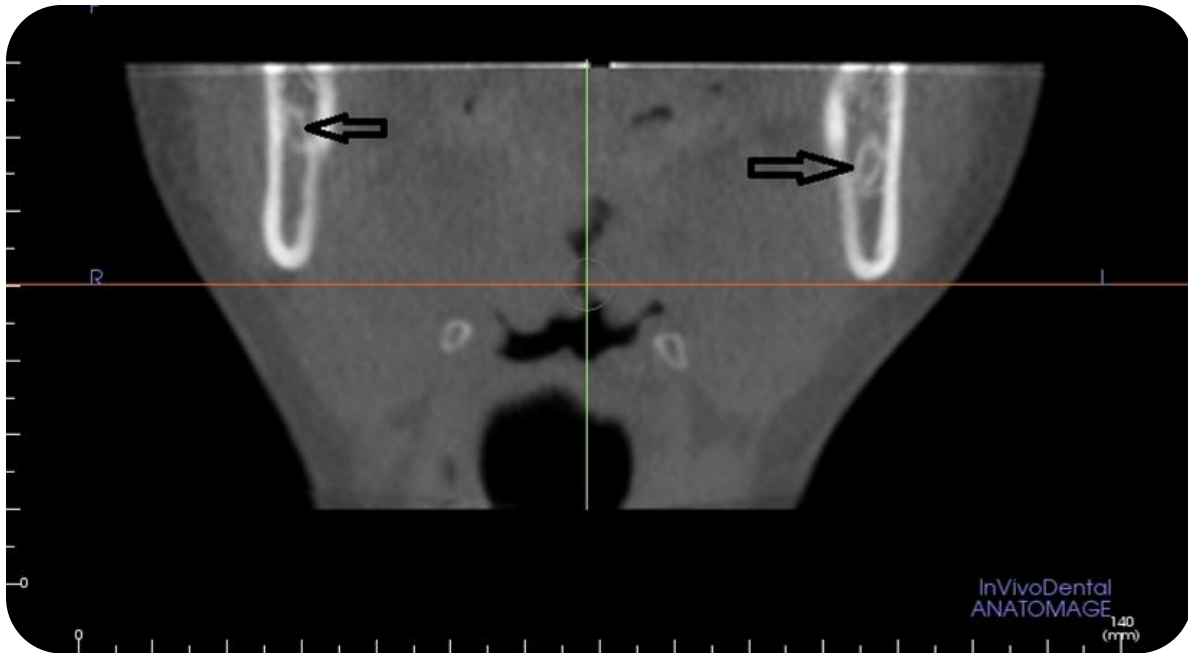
A coronal section of the mandible at the ramus level, showing the cross-sections of the right and left Mandibular Canals (black arrows) on right and left sides (Images obtained with i-CAT® Model 17-19; CBCT Imaging Unit: InVivoDental5 Version 5.2 Anatomage, software); Dentomaxillofacial Radiology Department; Faculty of Dentistry- University of Yeditepe.
